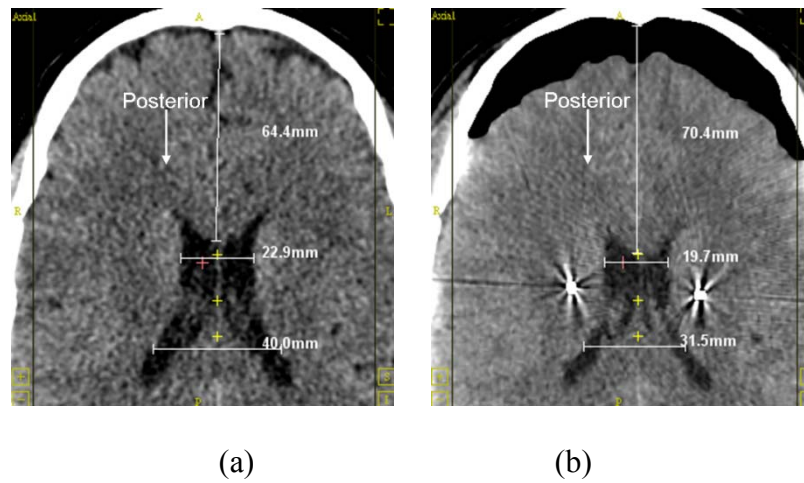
Corresponding axial slices of (a) pre-operative CT and (b) post-operative CT acquired immediately after surgery. Measurements of the ventricles indicate posterior shift and shrinking or medial contraction of the ventricles post-operatively.
